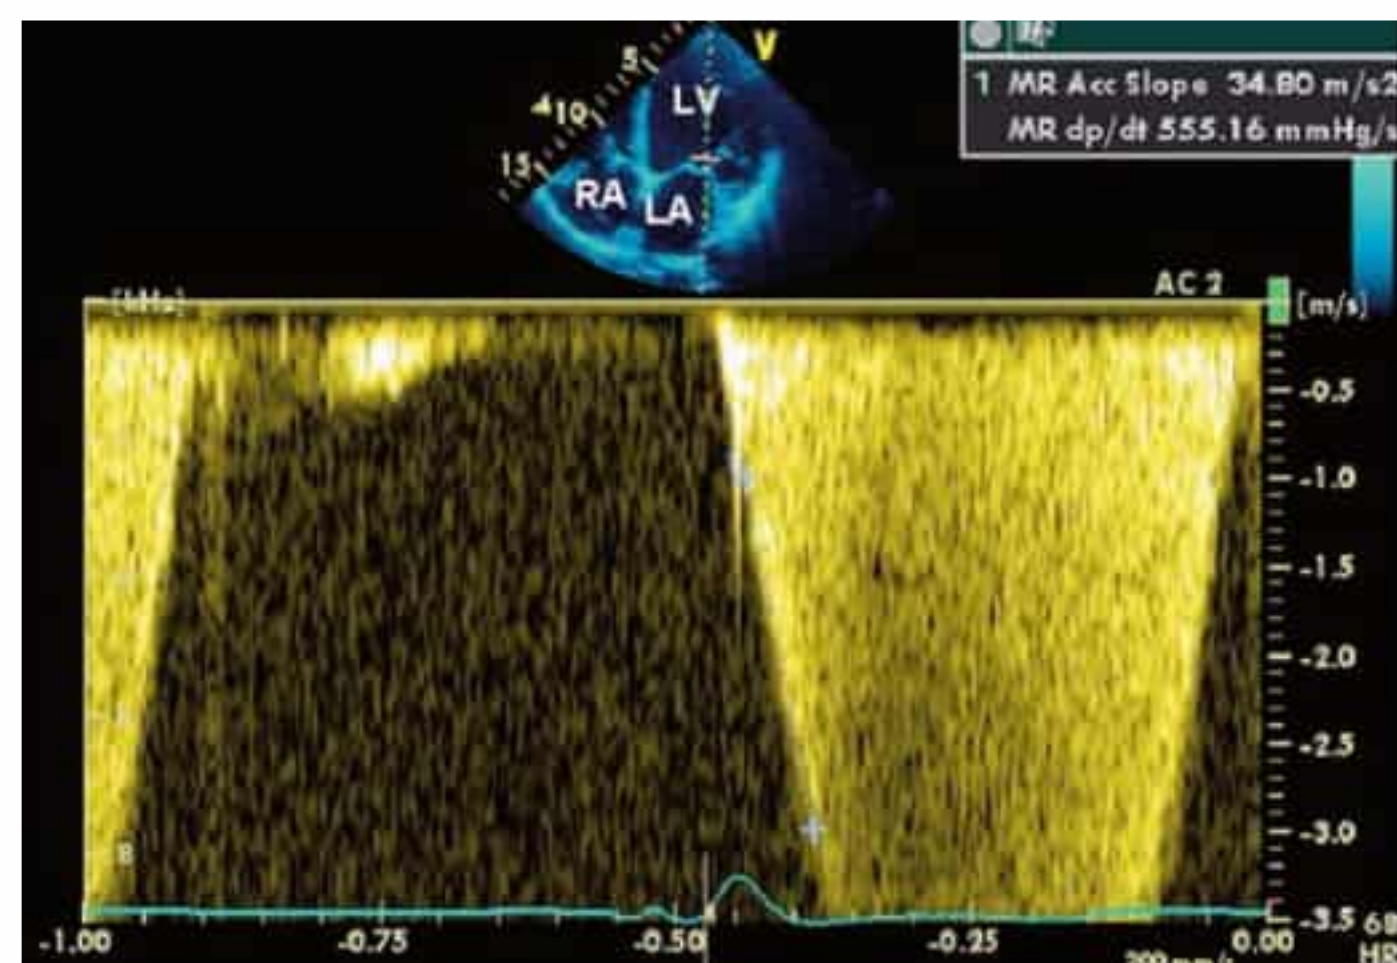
Continuous-wave Doppler in the four-chamber view in case of mitral regurgitation (MR). The beam extends from the left ventricular apex to the roof of the left atrium. The contractility parameter (dp/dt) is calculated from the interval between the time points corresponding to velocities of 1 m/s and 3 m/s in mm Hg/s.
